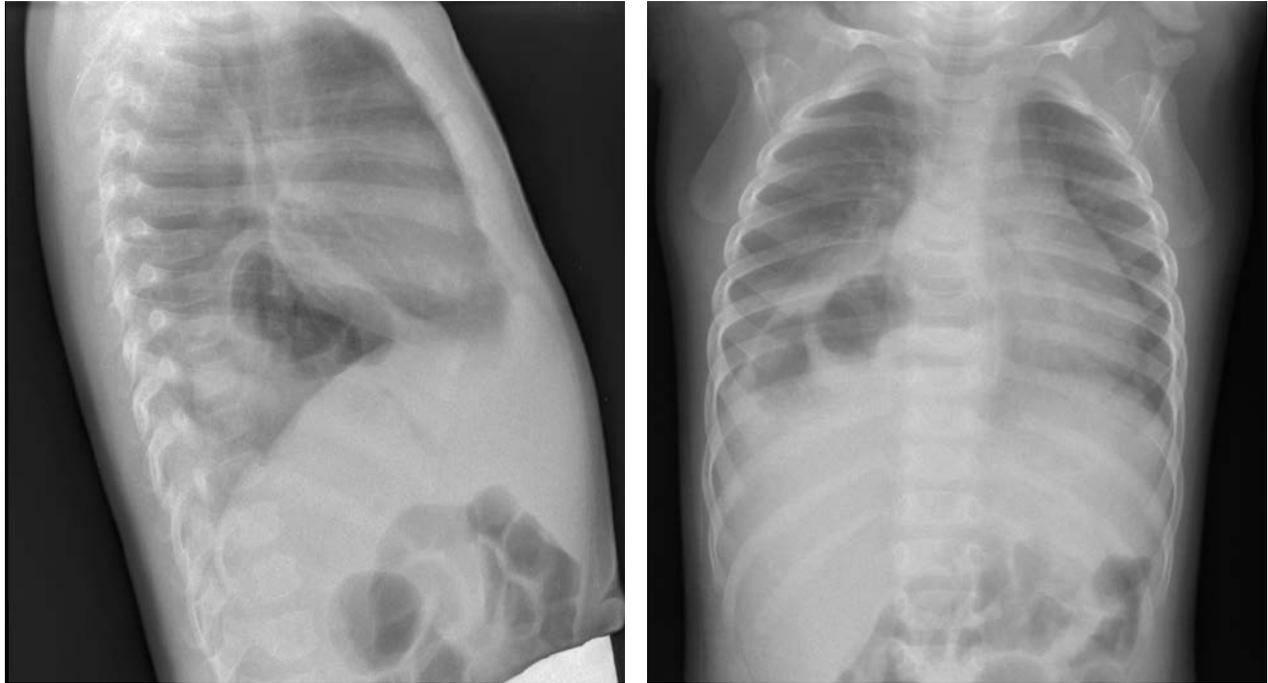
Lateral and anteroposterior X-ray demonstrating a thoracic hydroaerial mass.
